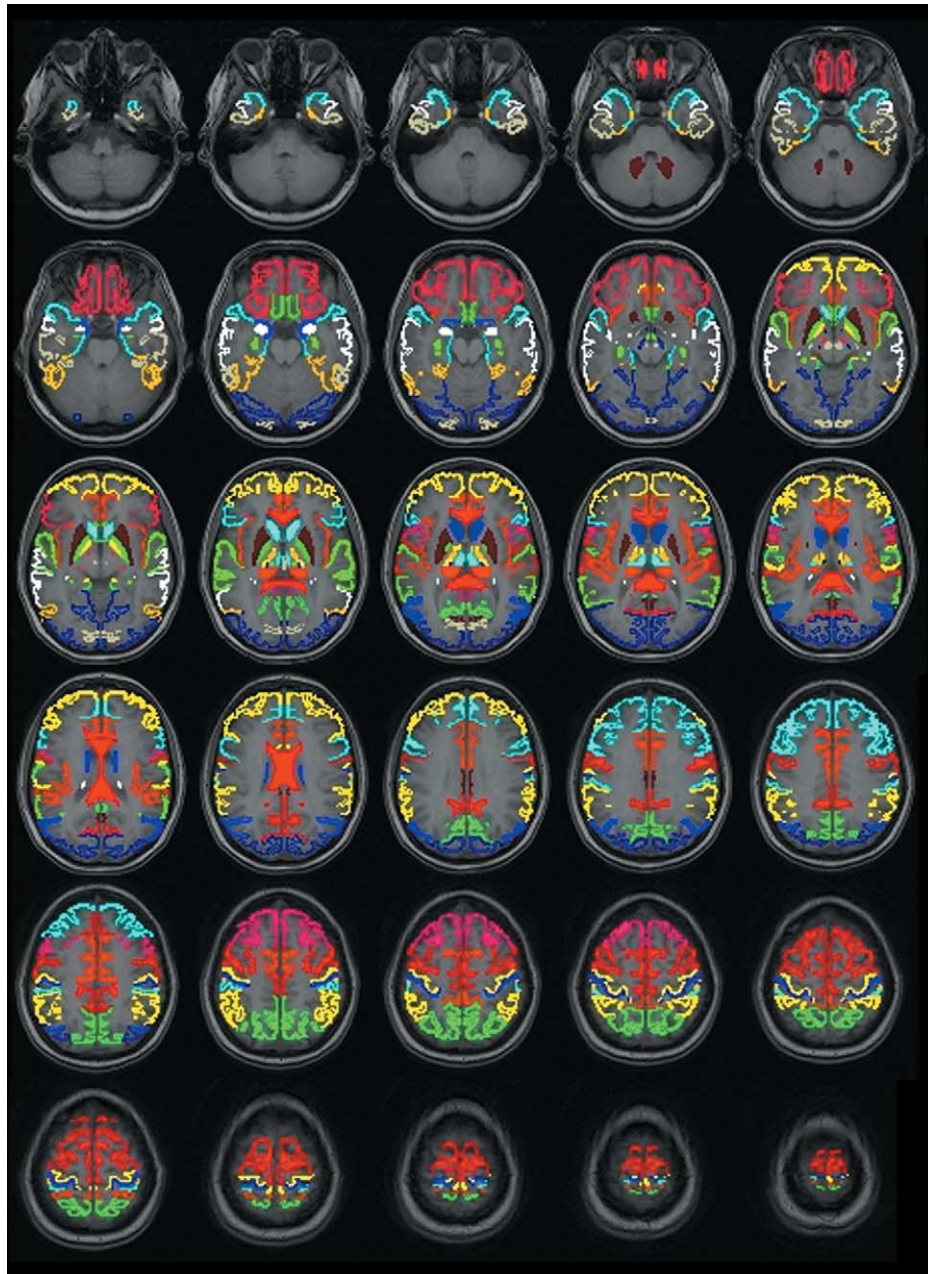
MNI Brodmann atlas overlaid on single subject MRI. Images are representative slices at 4-mm intervals. Individual Brodmann areas are color coded. In addition to Brodmann areas, the atlas includes subcortical structures including the basal ganglia, the geniculate nuclei, limbic structures, the corpus callosum, and the thalamic nuclei (as returned from the Talairach Daemon).
